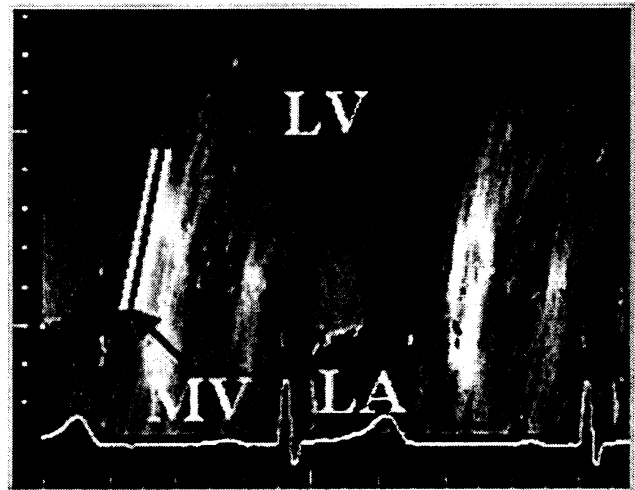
Color M-mode Doppler image demonstrating flow (generally color-coded) propagating from the left atrium (LA) across the mitral valve (MV) into the left ventricle (LV).
